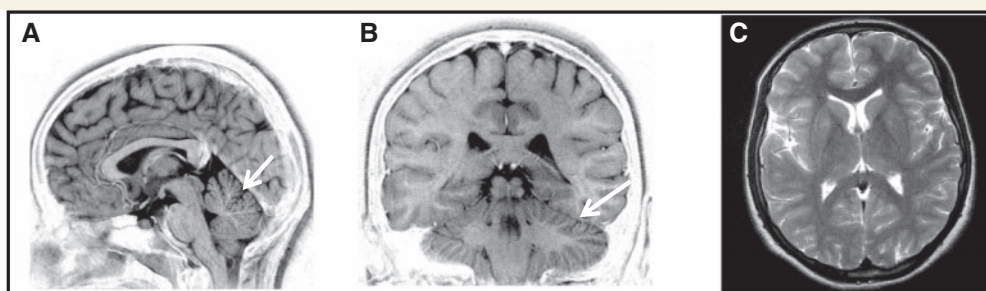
Brain MRI of Patient 2 (aged 18 years; at 9 years, brain imaging was essentially normal). Arrows point to dilated interfoliar sulci. (A) Sagittal inverted T₂-weighted image showing moderate cerebellar vermis atrophy. (B) Coronal inverted T₂-weighted image showing mild atrophy of the cerebellar hemispheres and prominent folia. (C) Transverse T₂-weighted image at the level of the basal ganglia. There are no hyperintense signals or white matter alterations.
